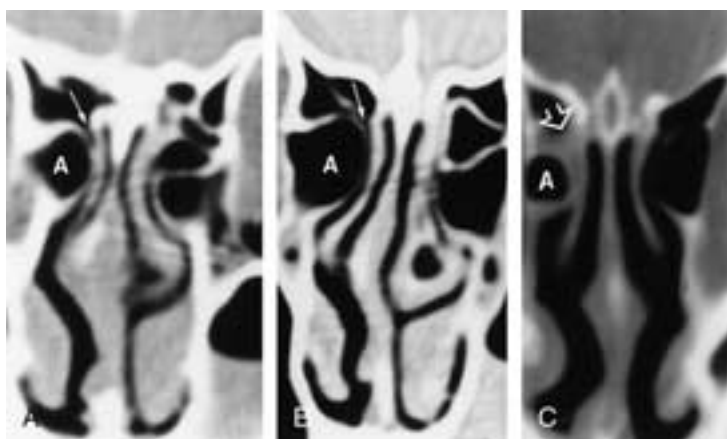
Anatomy of the frontal recess. A and B, Coronal CT images reveal a patent frontal recess (*white arrow*) despite the presence of a large agger nasi cell (*A*). C, Coronal CT image in a different patient with an obstructed right frontal recess and mucoperiosteal thickening in the right frontal sinus (*open arrow*). Agger nasi (*A*).
